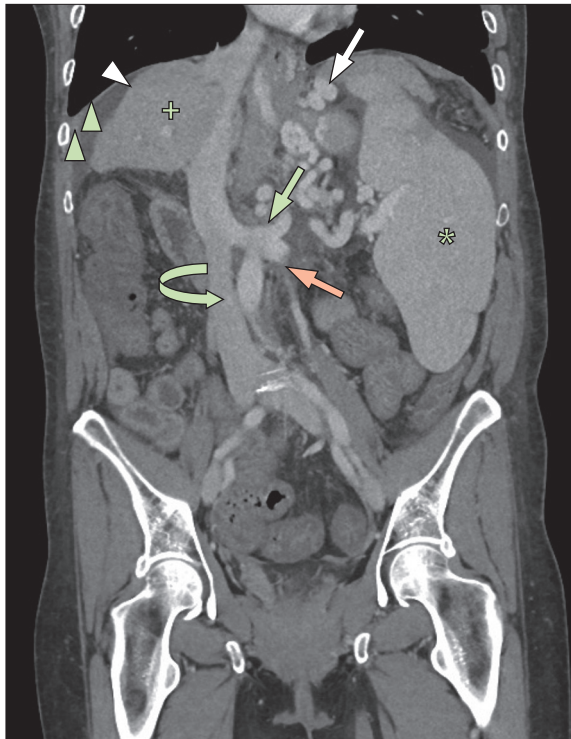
Coronal CT image of the abdomen in a patient with cirrhosis
